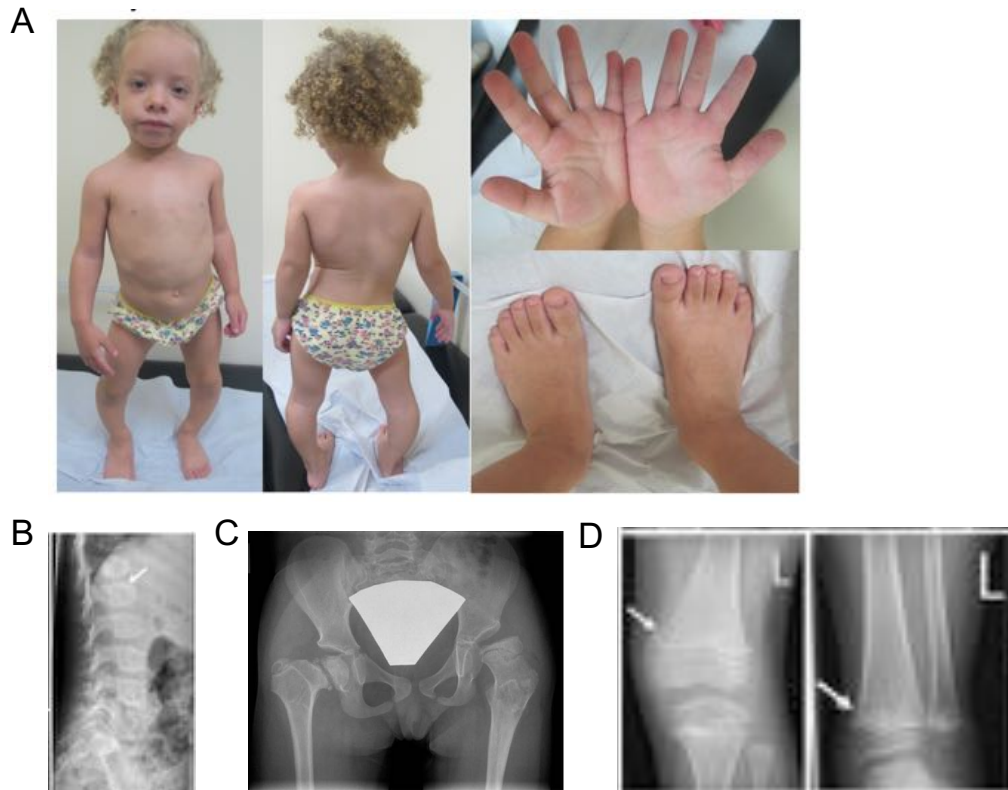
Clinical features of patients with SMD with corner fractures. (A) Affected child with scoliosis and genu varum. Normal hands and feet. (B) Image of the spine showing oval vertebral bodies. (C) Radiograph of pelvis and hips showing coxa vara. (D) Arrows indicate corner fractures. Images from Lee et al., 2017 [106].
